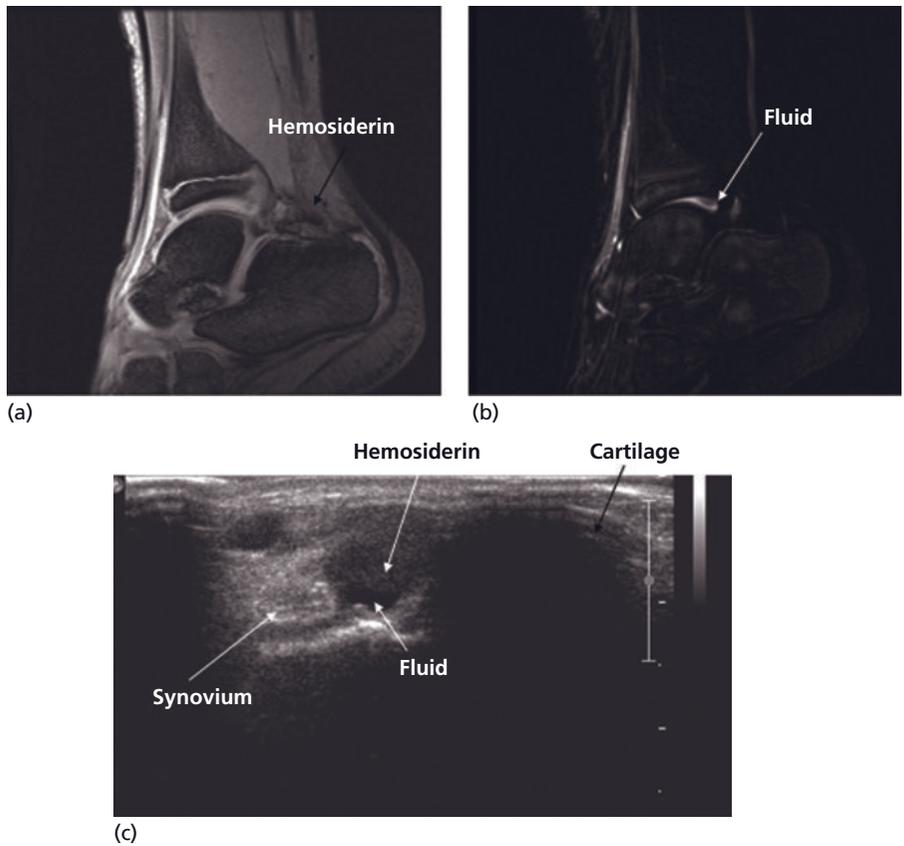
Sagittal gradient-echo (a) and T2-weighted (b) images of a hemophilic ankle show a mild amount of hemosiderin deposition and joint effusion. Only minimal “blooming” (susceptibility artifact) is noted within the posterior synovial recess of the ankle; however, the synovium is not promptly identified on the gradient-echo images. A corresponding sonogram demonstrates the conspicuity of the sonographic technique which allows easy discrimination between synovium (echogenic, “white”), hemosiderin (hypoechoic, “gray”), and fluid (anechoic, “black”).
